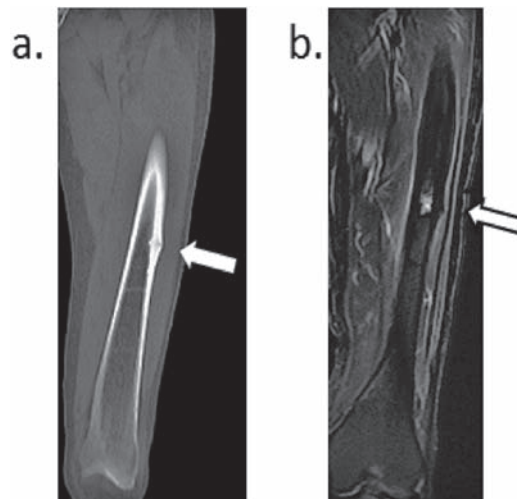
Computed tomography and magnetic resonance imaging scans showing a left femur fracture
